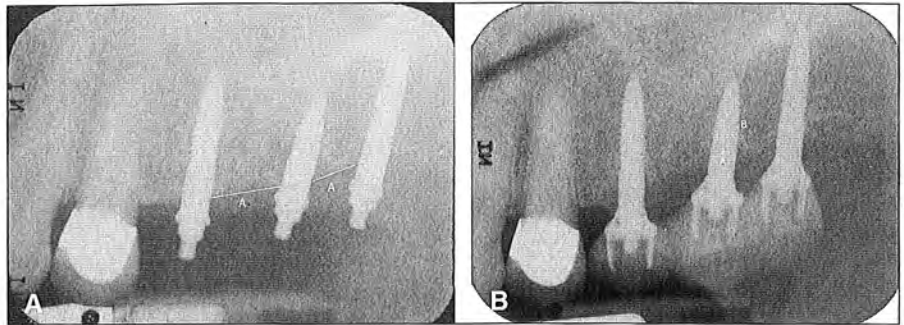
Radiographic assessment of bone levels around the implants. A, Periapical radiograph of the implants taken right after placement. The level of smooth and first screw junction was labeled as “A,” and this is the reference for future bone level. B, Periapical radiograph taken of the provisionalized NBLs at the 12-month follow-up visit. The label “A” represents the junction of smooth and first screw (the level of bone after remodeling) and label “B” indicated actual current bone level. The amount of bone loss was calculated at 1 year by subtraction of B from A.
